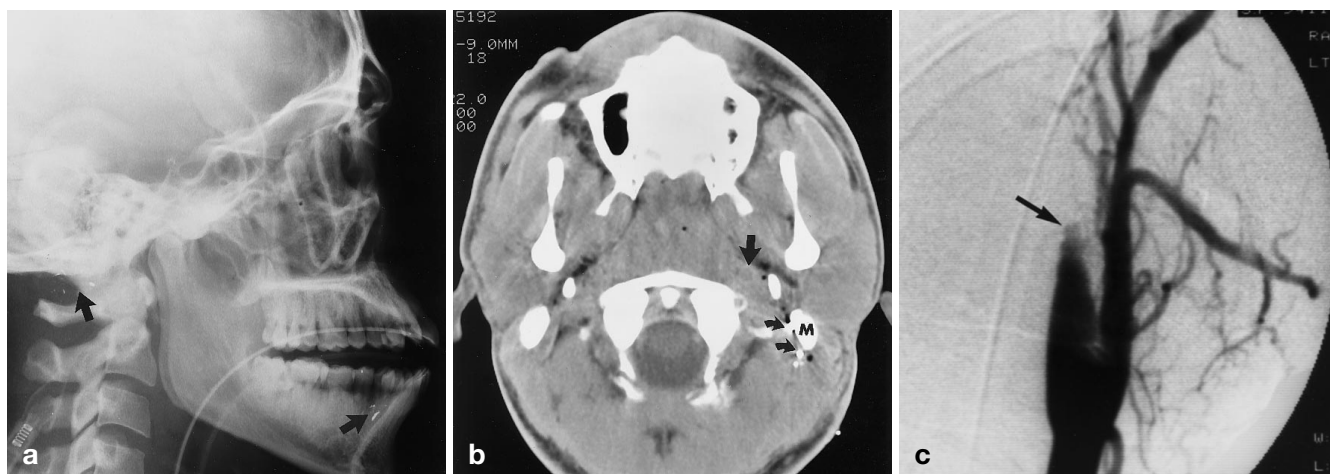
A young man sustained a gunshot wound to the neck. a A lateral plain film shows metallic fragments projecting over the mandible and adjacent to the mastoid tip (*arrows*), consistent with zone III injury. b An axial image from a noncontrast CT scan demonstrates metallic fragments (*curved arrows*) medial to the left mastoid tip (*M*). The pattern of air in the deep tissues and the presence of fragments near the mandible and mastoid as shown in a indicate that the trajectory of the missile passed close to the left internal carotid artery (*straight arrow*). c A lateral projection from a left common carotid angiogram demonstrates occlusion of the left internal carotid artery (*arrow*)
